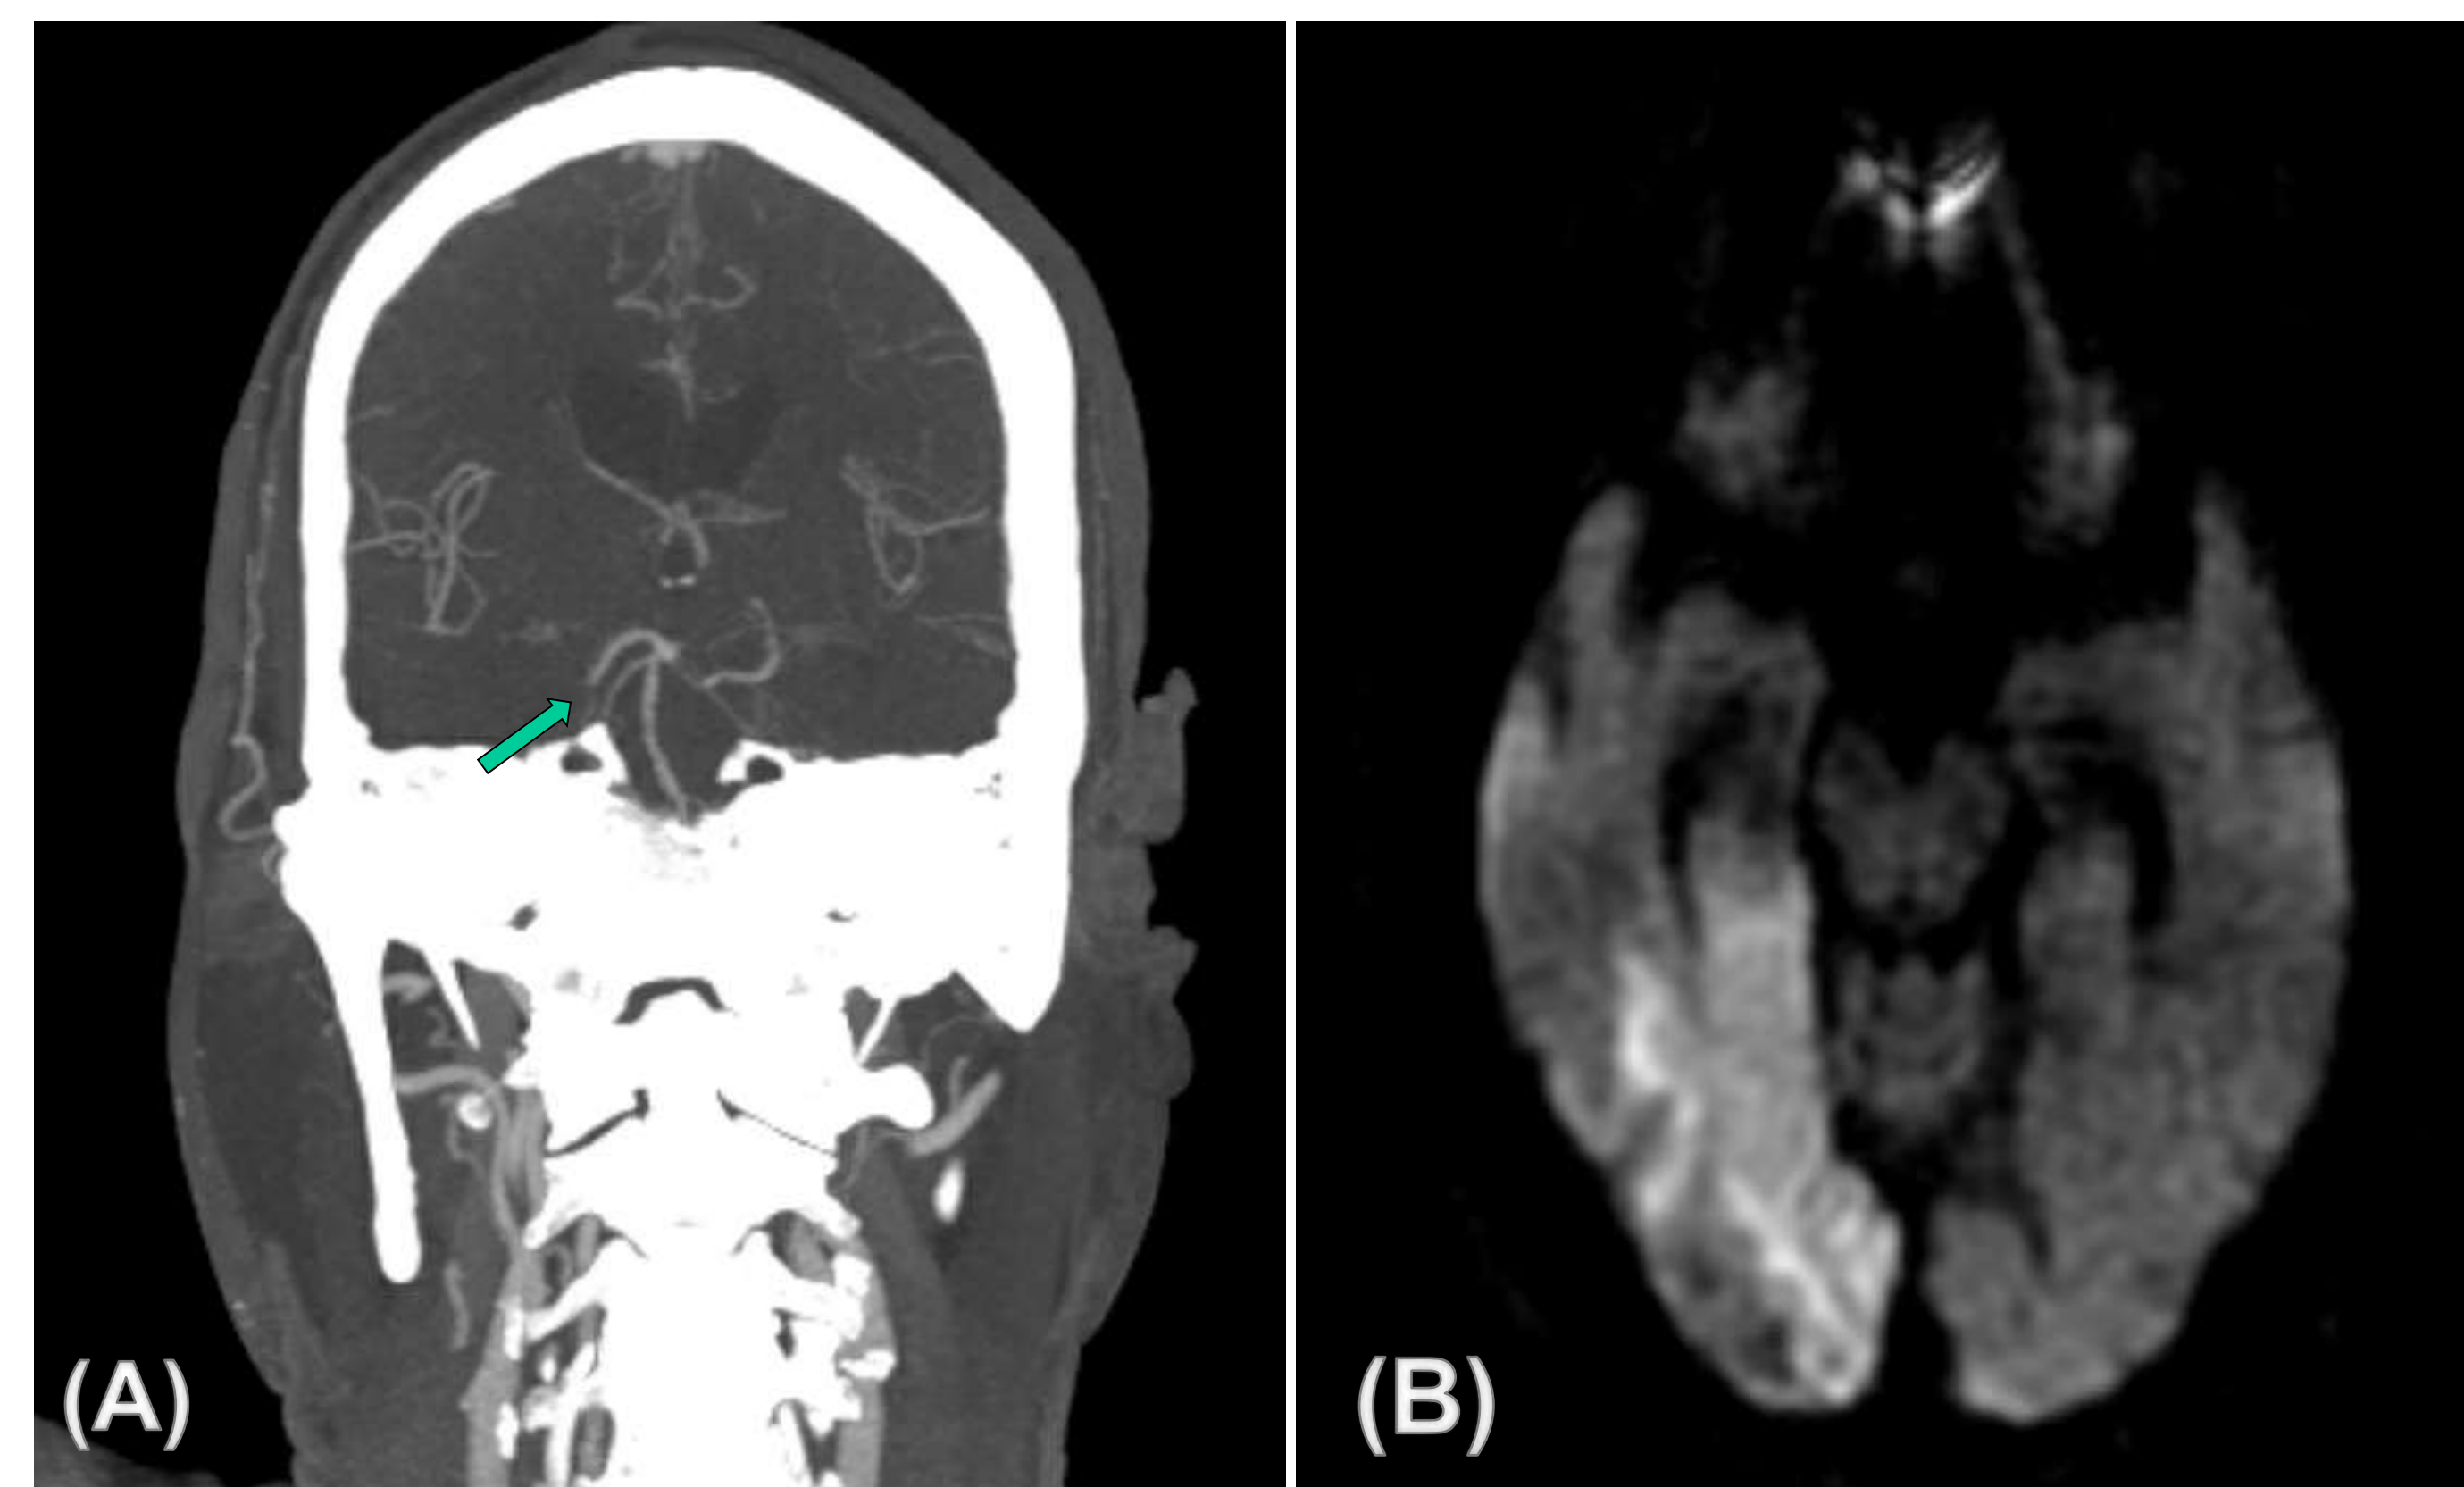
Brain Imaging showing acute stroke. (A): CT Angiography of the head (coronal view) is showing an abrupt cut of the right posterior cerebral artery PCA at the P1-P2 segments junction (green arrow). (B): MRI brain shows diffusion restriction on DWI in the right occipital and mesial temporal lobes in the right PCA territory.
